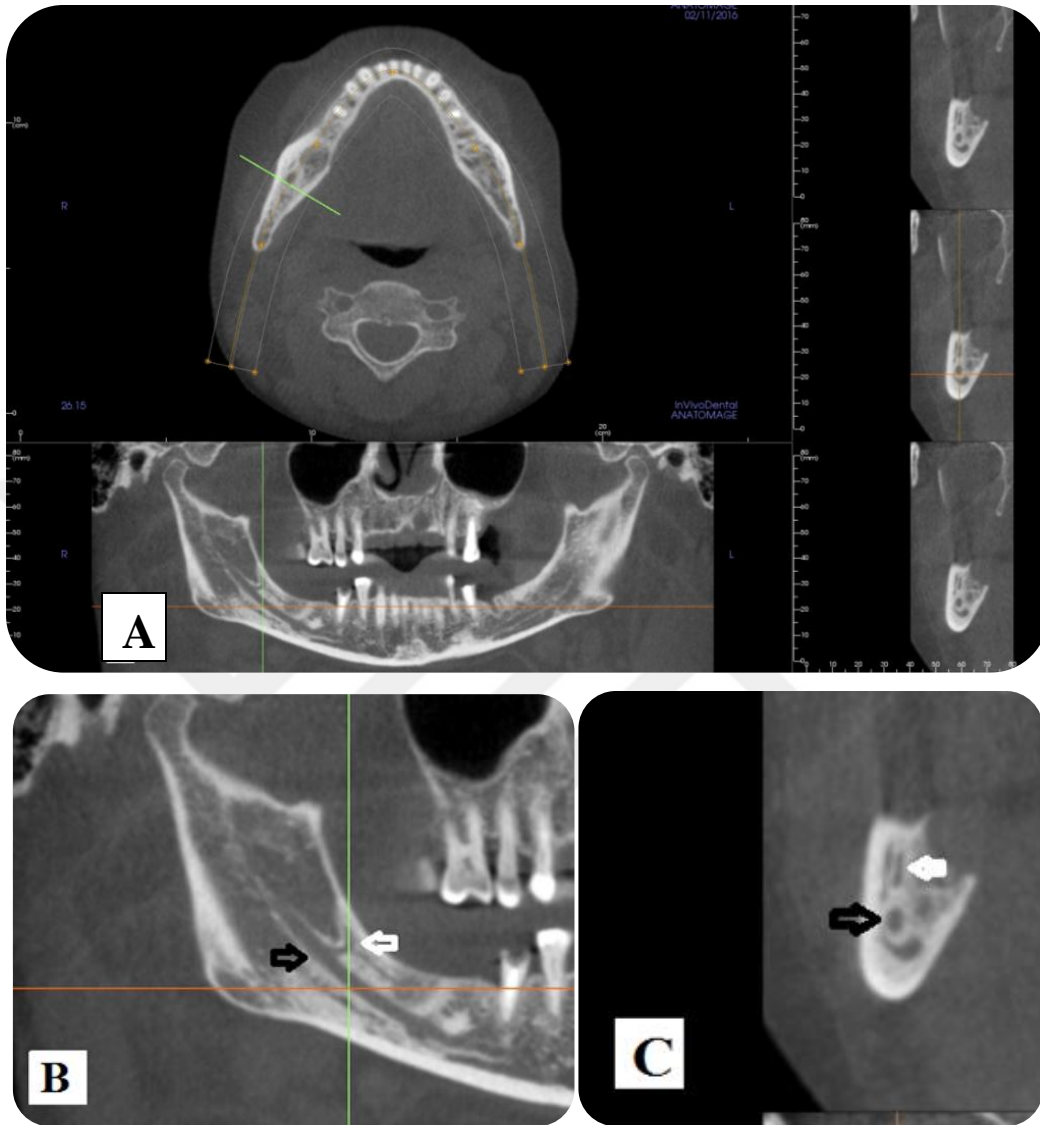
Multi-planar Reformation Arch Section. A: a reformatted panoramic view, showing a curved retromolar canal with a horizontal branch (Type B2) at the right side of the mandible, and serial cross-sections; 0.125mm-interval slices. B: cropped magnified image from the same section; black arrow denoting the mandibular canal at the level of RMC, and white arrow denoting the RMC at the level of the horizontal branch. C: a cross-section of the RMC; black arrow denoting the mandibular canal and white arrow denoting the RMC with the horizontal branch (Images obtained with i-CAT® Model 17-19; CBCT Imaging Unit: InVivoDental5 Version 5.2 Anatomage, software): Dentomaxillofacial Radiology Department; Faculty of Dentistry-University of Yeditepe.
